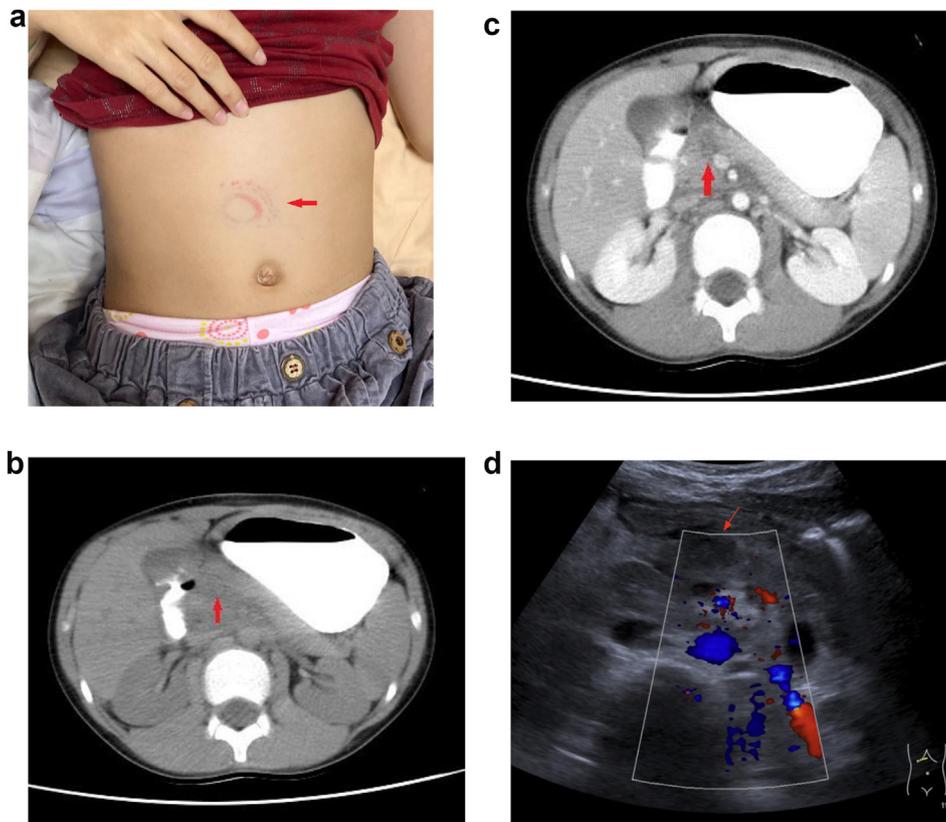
A: Torso handlebar bruise over the upper abdominal quadrant, B: Non-enhanced abdominal computed tomography revealed a distended stomach filled with radiopaque oral water-soluble contrast medium, which masked the subtle pancreatic head lesion (arrow) as seen. C: Intravenous contrast-enhanced abdominal computed tomography revealed a focal ill-defined poorly-enhanced pancreatic head contusion injury (arrow). D: Abdominal Doppler sonography on the 3rd day showed a focal hypoechoic pancreatic head lesion (arrow).
